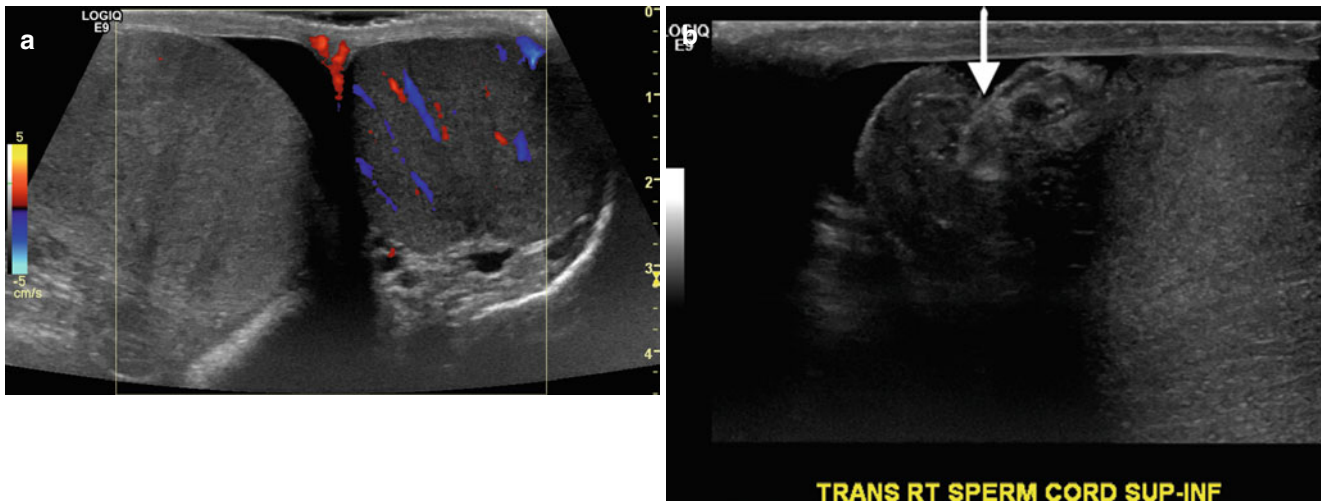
Testicular torsion. Gray-scale and color Doppler images of the testes and gray-scale image of the spermatic cord in a young man presenting with acute right scrotal pain. (a) Color Doppler side-by-side transverse image demonstrates the absence of vascular flow to the right
